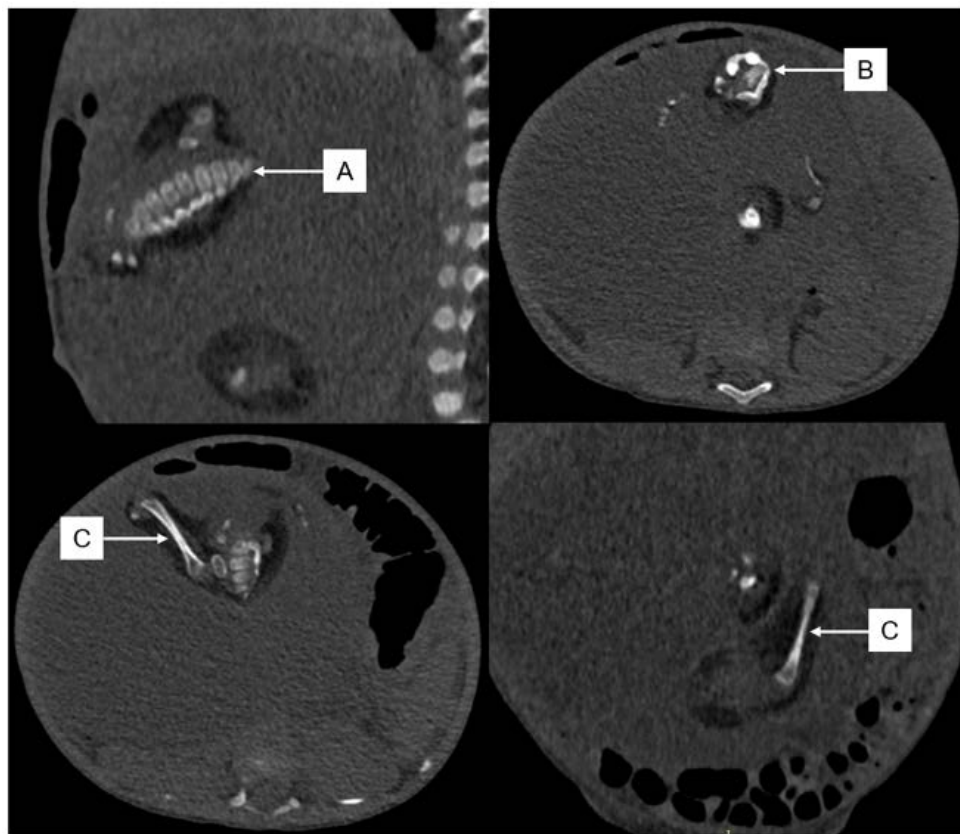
Abdominal contrast-enhanced computed tomography scan, axial, sagittal, and coronal views of a 4-month-old male with fetus in fetu showed a large intra-abdominal, retroperitoneal mass, with heterogeneous density predominantly hypodense measuring about 13.18 x 10.77 x 12.53 cm. It contained solid densities resembling a fetus-like structure measuring about 7.35 x 8.44 x 9.43 cm with spine (A), pelvis (B), femur (C), and cystic components inside.
